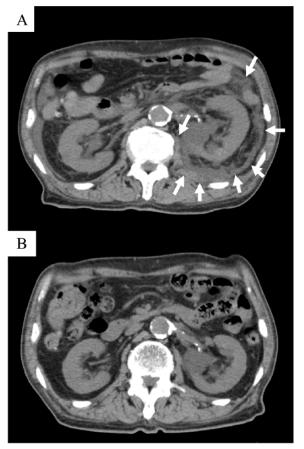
Transverse plane of abdominal and pelvic computed tomography images (A) on admission and (B) 2 weeks after admission.
